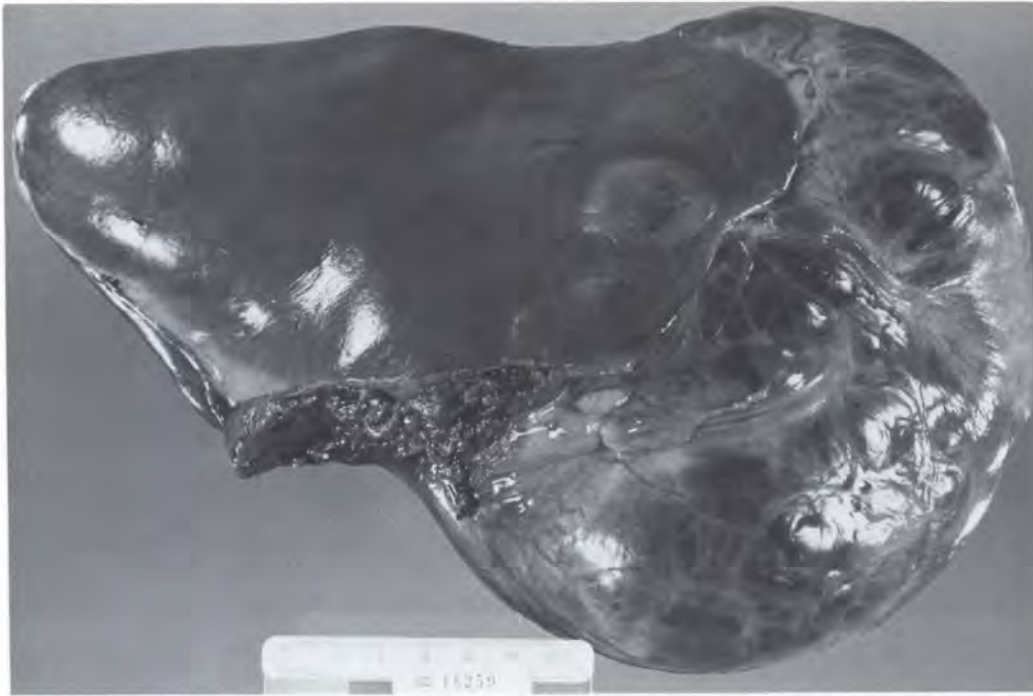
Large hepatocellular adenoma (18 × 16 × 12 cm) occupying most of the left lobe of the liver. A partial lobectomy was performed in this patient, who had a long history of oral contraception before conception. The tumor was found at 12 weeks of gestation. Therapeutic abortion failed to induce regression of the tumor. Its cut surface was lobulated, focally necrotic, and hemorrhagic, thus confirming a CT scan impression. The tumor was negative for estrogen and progesterone receptors, but the adjacent normal liver was positive.
